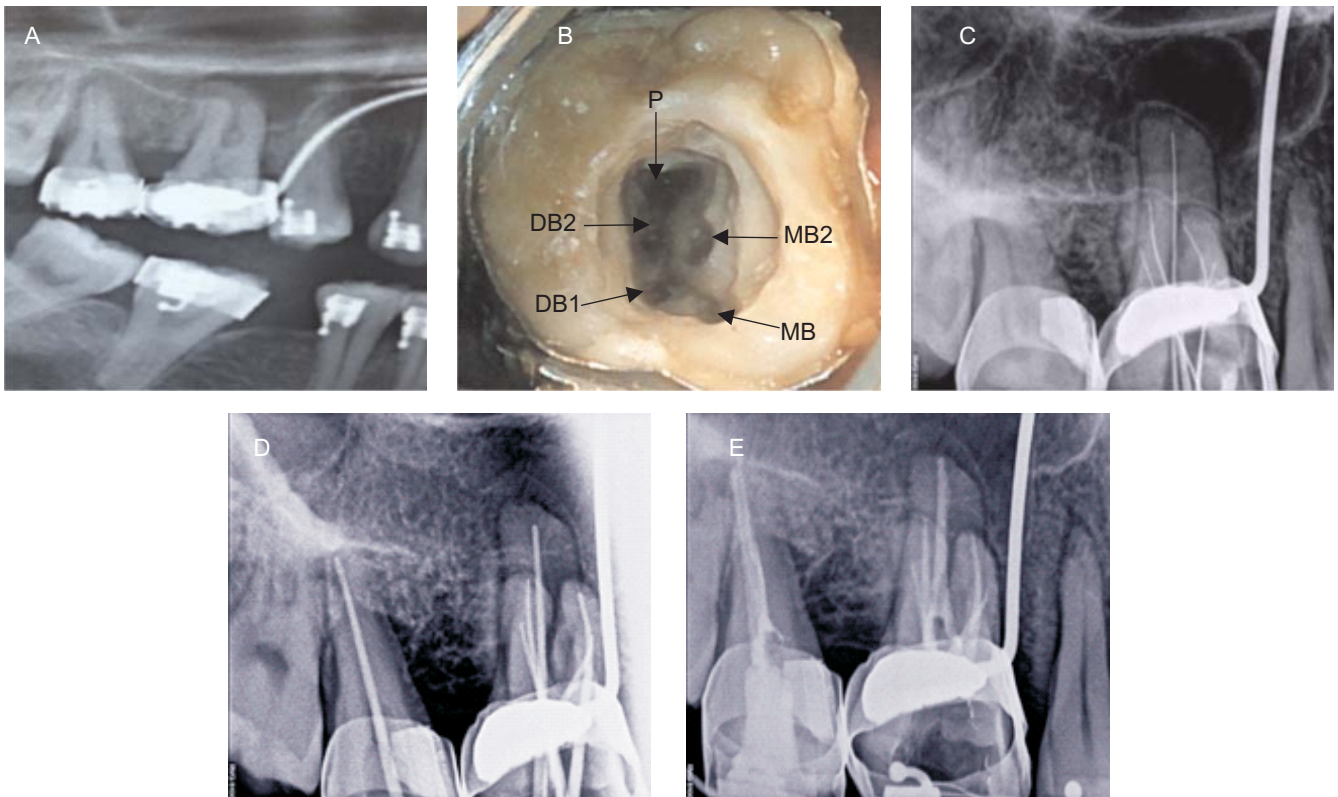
A: Preoperative radiograph of #3, B: Access opening showing five root canal orifices, C: Working length radiograph of #3 in eccentric angulation, D: Master cone radiograph, E: Postobturation radiograph.
